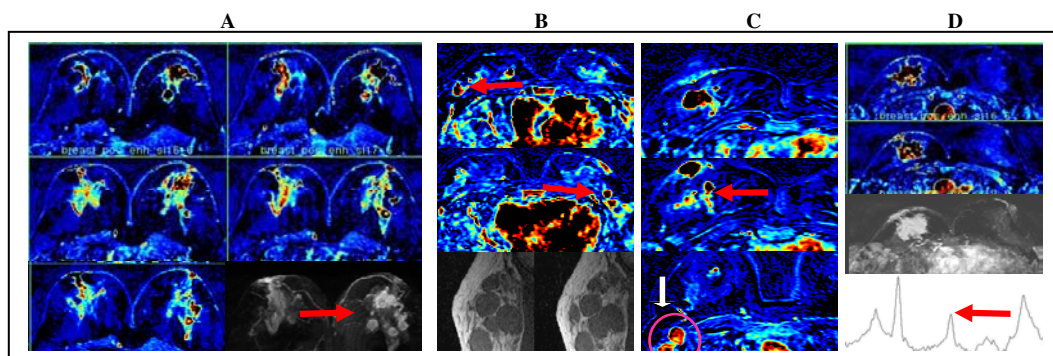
MR imaging of ER-negative breast cancer. A: Multiple cancers in left breast. B: Bilateral breast cancers with confluent lymph nodes. C: Multiple cancers with lymph nodes. D: Irregular tumor with detectable choline
